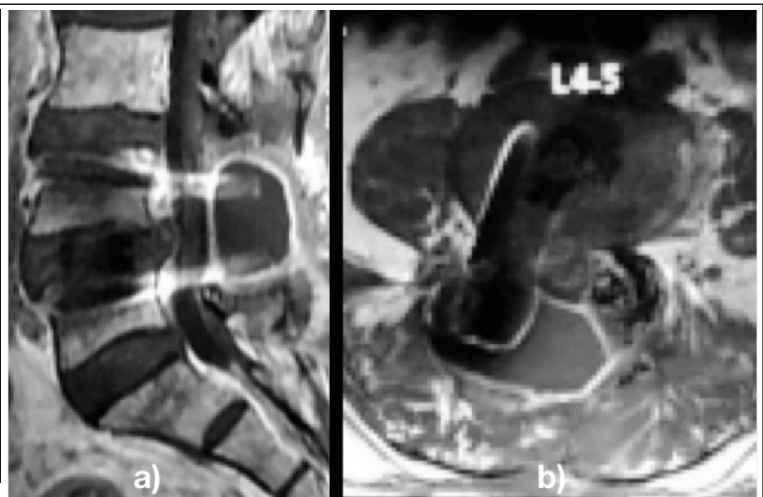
Pus collection around the implants on MRI
